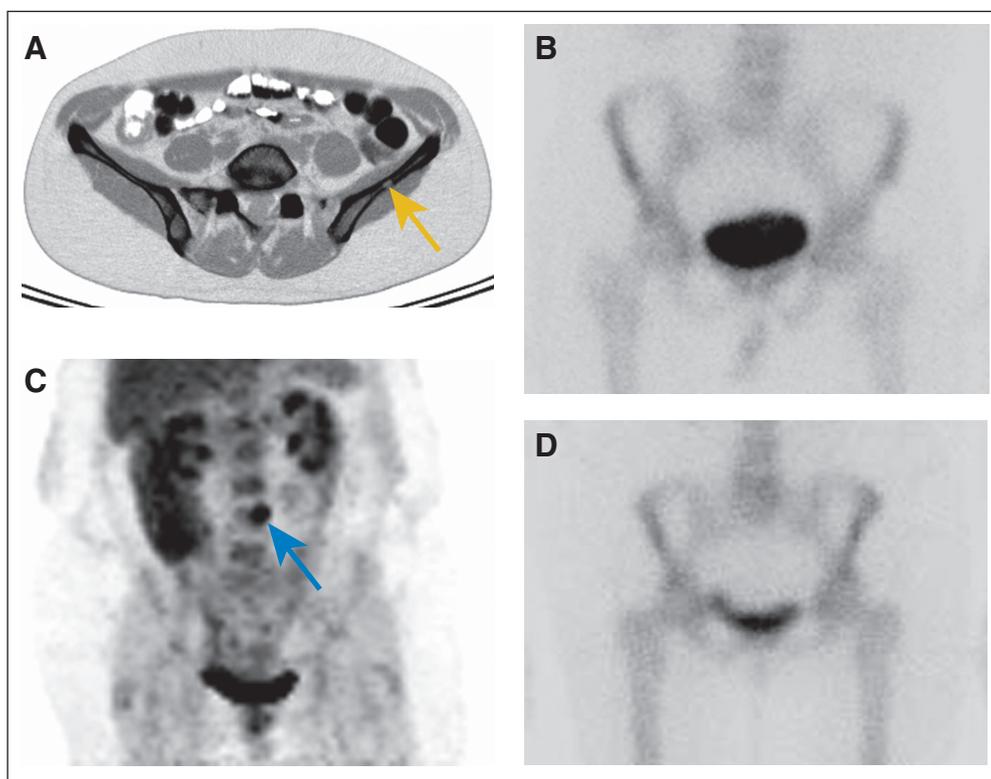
Example of discordant positron emission tomography (PET)/computed tomography (CT) and bone scintigraphy results. A 45-year-old woman with biopsy-proven left iliac osseous metastasis detected on (A) axial PET/CT image (gold arrow), but (B) not bone scintigraphy. A 58-year-old woman with biopsy-proven metastatic breast cancer to (C) L4 on coronal PET image (blue arrow), but (D) not bone scintigraphy.
